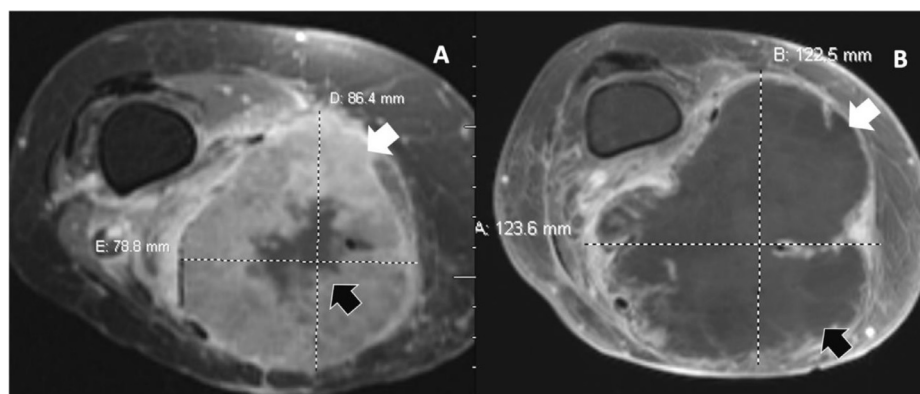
A 83-year-old woman with a high-grade unspecified pleomorphic sarcoma arising from the flexor compartment of the right thigh. (A) Axial fat saturated (FS) postintravenous gadolinium contrast (all contrast in the article is gadolinium-based unless stated otherwise) T1-weighted image (WI) demonstrates a heterogeneous soft tissue mass within the distal thigh, displaying thick peripheral solid enhancement (white arrow) and mild central necrosis (black arrow) before treatment. (B) Axial FS postcontrast T1-WI of the same tumor after chemo-radiation demonstrates increased size due to increased central necrosis (black arrow). The interval reduction of the peripheral solid enhancement (white arrow) indicates a positive response to therapy despite the increase in size. This phenomenon is termed “pseudoprogression.”
